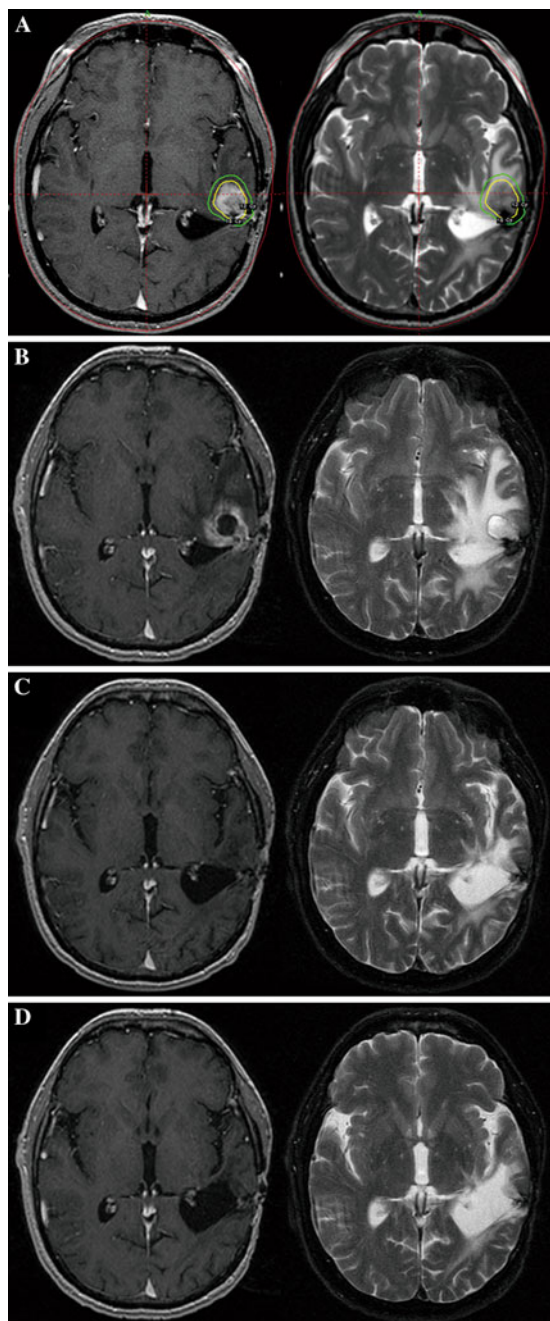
Magnetic resonance imaging (MRI) of a patient (case 5) with recurrent glioblastoma multiforme who underwent gamma knife stereotactic radiosurgery (GKSr) followed by combination treatment of bevacizumab and temozolomide. In comparison with MRI scan at the time of GKSr (a), subsequent MRI scan after first cycle of chemotherapy (b) showed progressive changes in T1- and T2-weighted image. Two months later, the contrast enhancing lesion disappeared with improvement of T2 changes (c), indicating that the initial MRI demonstrated pseudoprogression. The enhancing tumor was not seen on MRI scan (d) at 14 months after GKSr (complete response)
